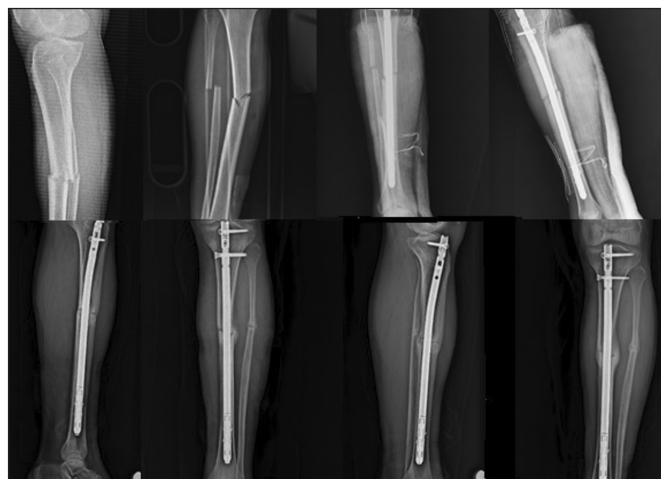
The appearance of the intramedullary nail in the direct radiographs of the patients
